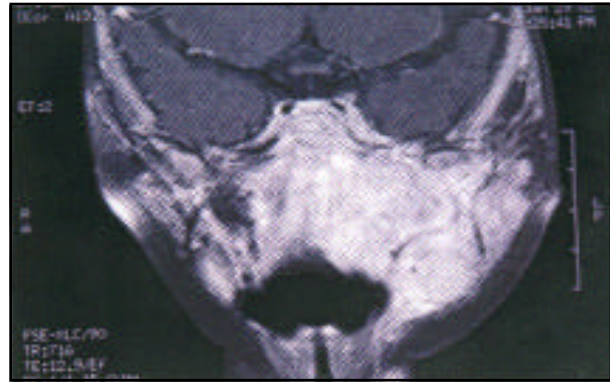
Coronal T1 weighted MRI of the head demonstrates an enhanced hyperintense mass lesion located in the left parotid region and extending to the para pharynx.
